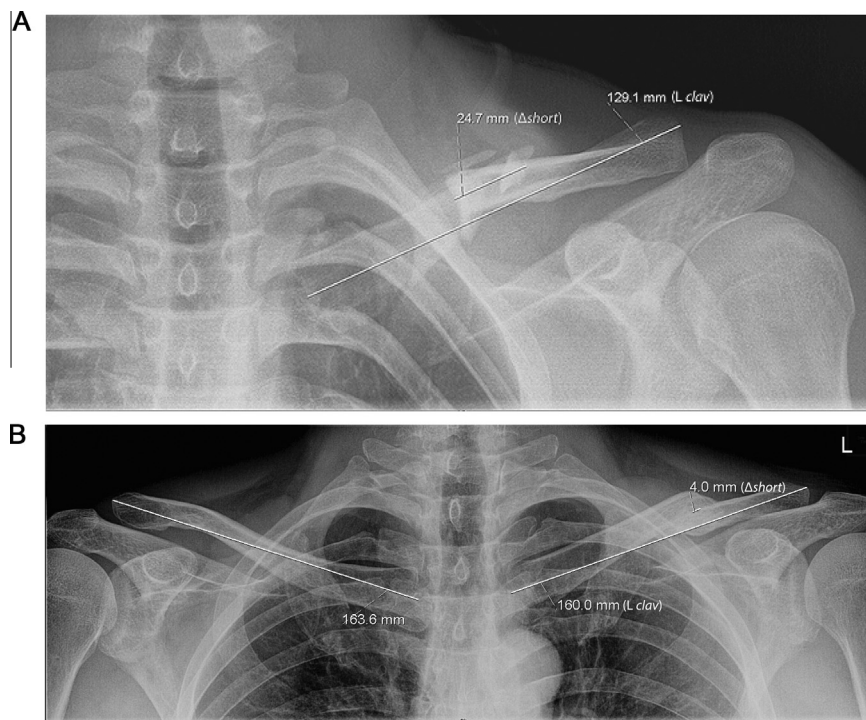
Measurement of clavicular length and shortening after a midshaft fracture, on the anteroposterior trauma radiograph (A) and anteroposterior panorama radiograph (B). Fig. 1A: Clavicular length (*L clav*) is defined by the line connecting the middle of the medial border with the most lateral edge. Absolute shortening ($\Delta short$) was calculated by connecting the cortical fragments along the axial line of the clavicle. The Clavicular Shortening Index (CSI) is defined as the absolute shortening divided by the length of the affected clavicle plus absolute shortening. For this case, the relative shortening is $24.7 / (129.1 + 24.7) \times 100 = 16.1\%$. Fig. 1B: Clavicular length (*L clav*) is defined by the line connecting the middle of the medial border with the most lateral edge. The length of the consolidated clavicle (L) in this example is 160.6 mm and the length of the contralateral clavicle (R) is 163.6 mm. Absolute shortening ($\Delta short$) is defined as the axial distance between the cortical fragment ends. In this case, the absolute shortening is 4.0 mm. *A and B are from different patients.
